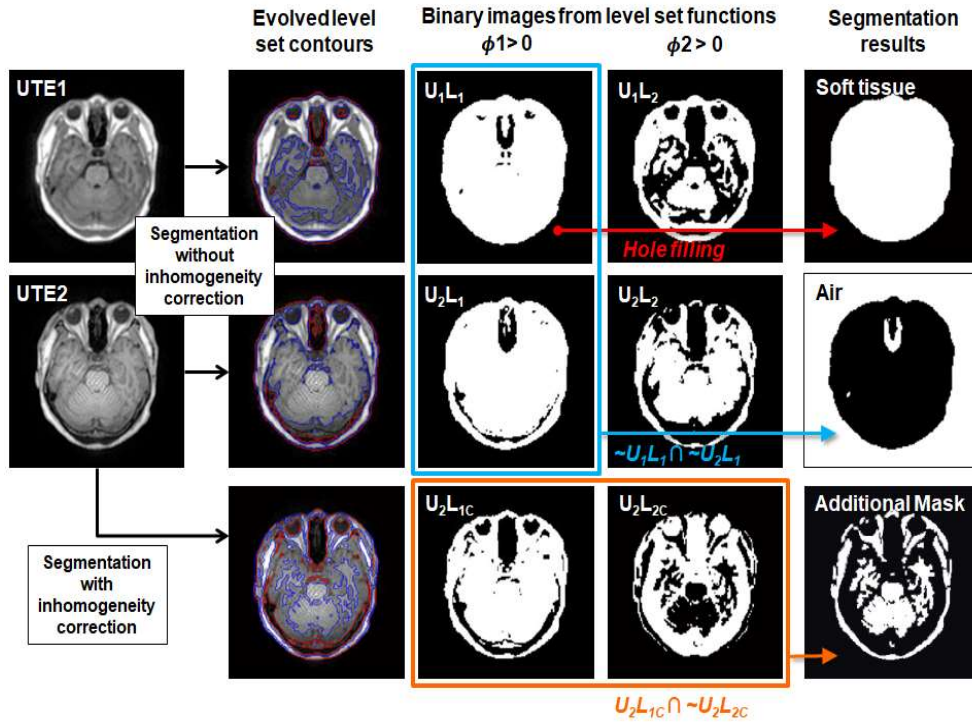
Generation of soft tissue and air maps and an additional mask using two-phase level segmentation and morphological and binary operations. The final evolved contours (red: level-set function 1 = 0, blue: level-set function 2 = 0) are overlaid on the MR images. U_xL_y is the binary image from the x^{th} level-set function of the y^{th} UTE. The soft tissue and air maps were generated by filling the holes in U_1L_1 and multiplying two binary images ($\sim U_1L_1$ and $\sim U_2L_1$). Additionally, a mask for trimming the bone map was generated from the binary images of the level-set functions obtained using the level-set segmentation with inhomogeneity correction ($U_2L_{1c} \cap \sim U_2L_{2c}$).
